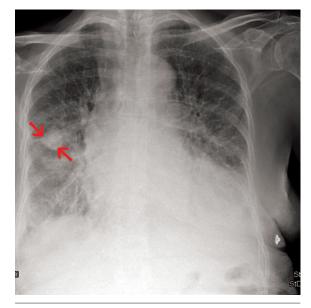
Radiograph of the chest at the time of admission.
